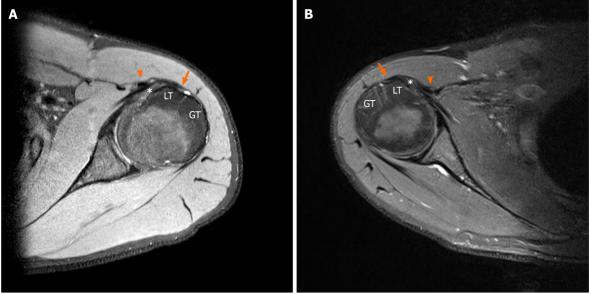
Computed tomography scan showing bicipital groove dysplasia. A: Left shoulder; B: Right shoulder.
